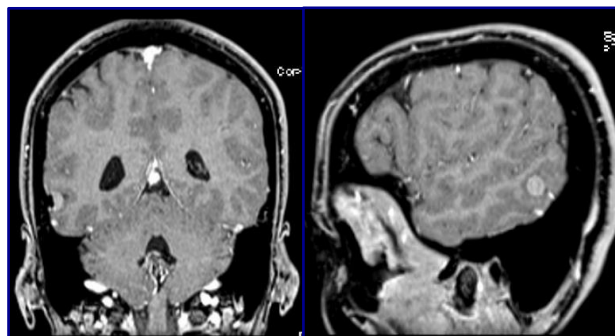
Brain MRI: T1, T2, and FLAIR sequence showing the right temporal lesion and hyperostosis.
